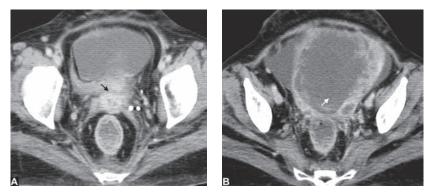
to D: CT Images show a moderately enhancing soft tissue density mass in left adnexa attached to superior lateral aspect of uterus. Left ovary is seen separately from the mass. This turned out to be a broad ligament fibroid on surgery
